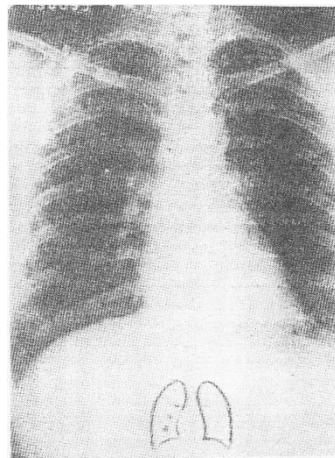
Chest X-ray film of a case where 32 metastatic lesions of the left lung have been removed cryosurgically.
